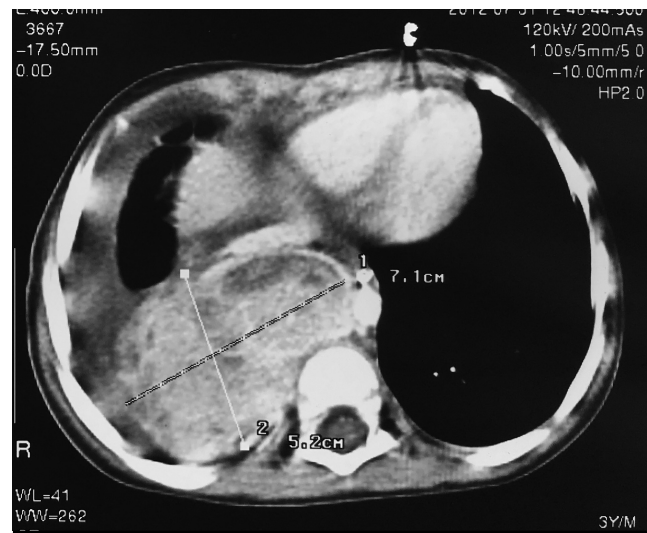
Computed tomography scan of the chest revealing extended right-sided pleural effusion and a large paraspinal lobulated mass in posterior mediastinum
